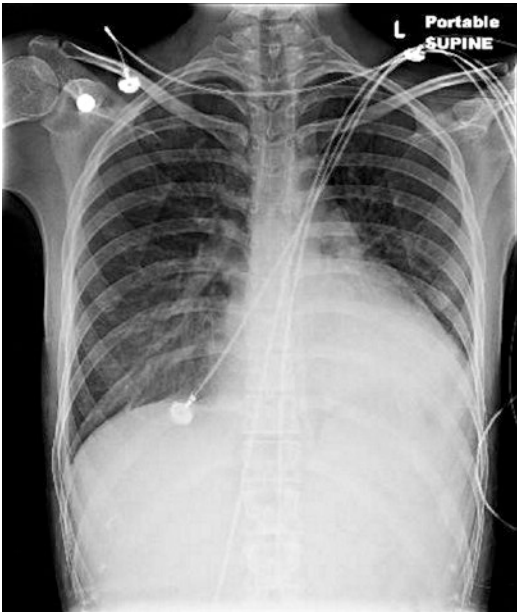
Chest X-ray on admission showing cardiomegaly without significant pulmonary congestion
